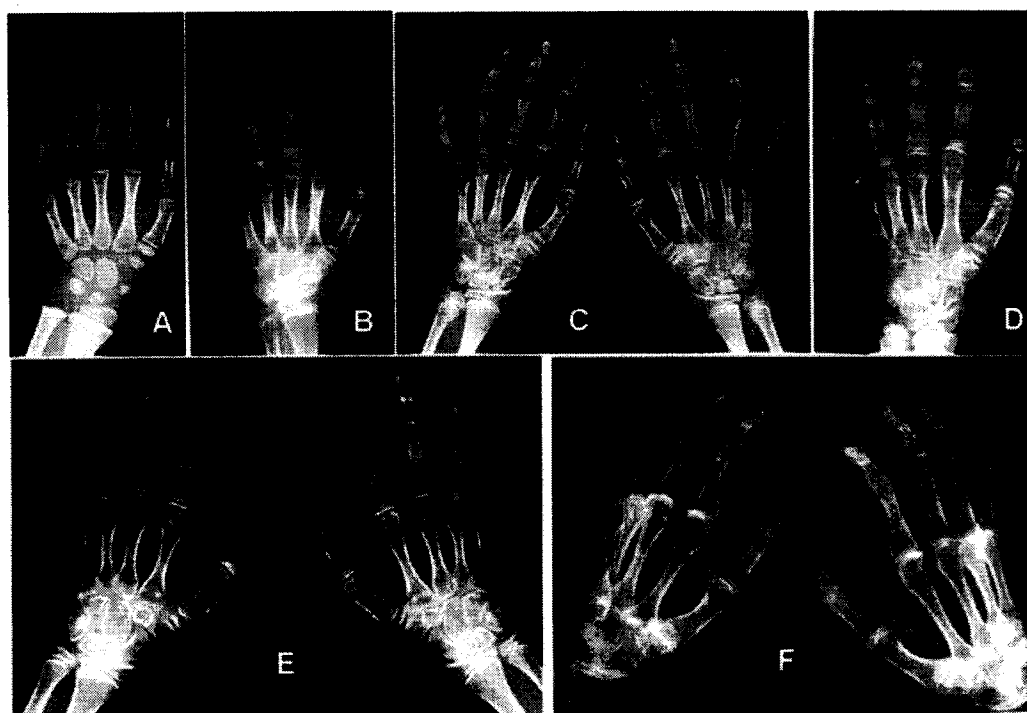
Bone changes in hand X-rays of different PPRD patients at different ages: at 6 years (A), minimal metaphyseal enlargement at the interphalangeal joints (IPJ), normal carpal bones; at later ages (B = 9 years; C and D = 10 years; E = 12 years) IPJ appear enlarged, with metaphyseal irregularities and the interosseous space between the carpal bones is reduced. Camptodactyly often appears in childhood (C and D = 10 years) and is always present in adulthood (F = 45 years) with reduced mobility of all hand joints.
